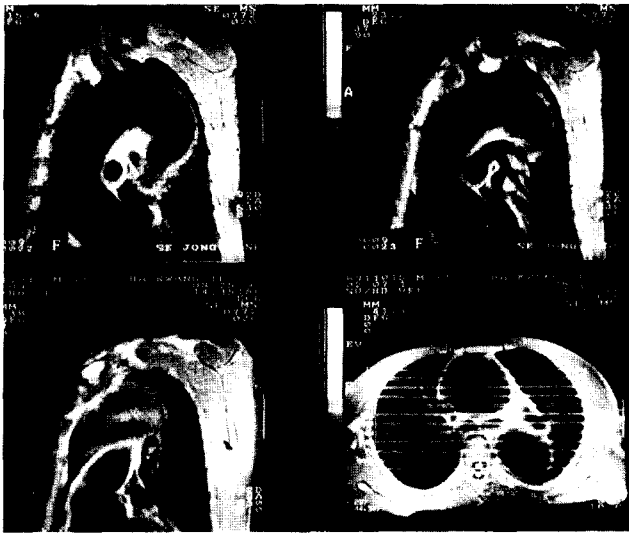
The MRI finding of a diffuse aneurysm involving ascending aorta, aortic arch and proximal descending aorta necessitating total arch replacement.
